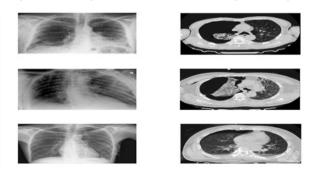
Radiological findings of pneumothorax in COVID-19 patients. The X-ray image is in the left column, and CT is demonstrated in the right column.
